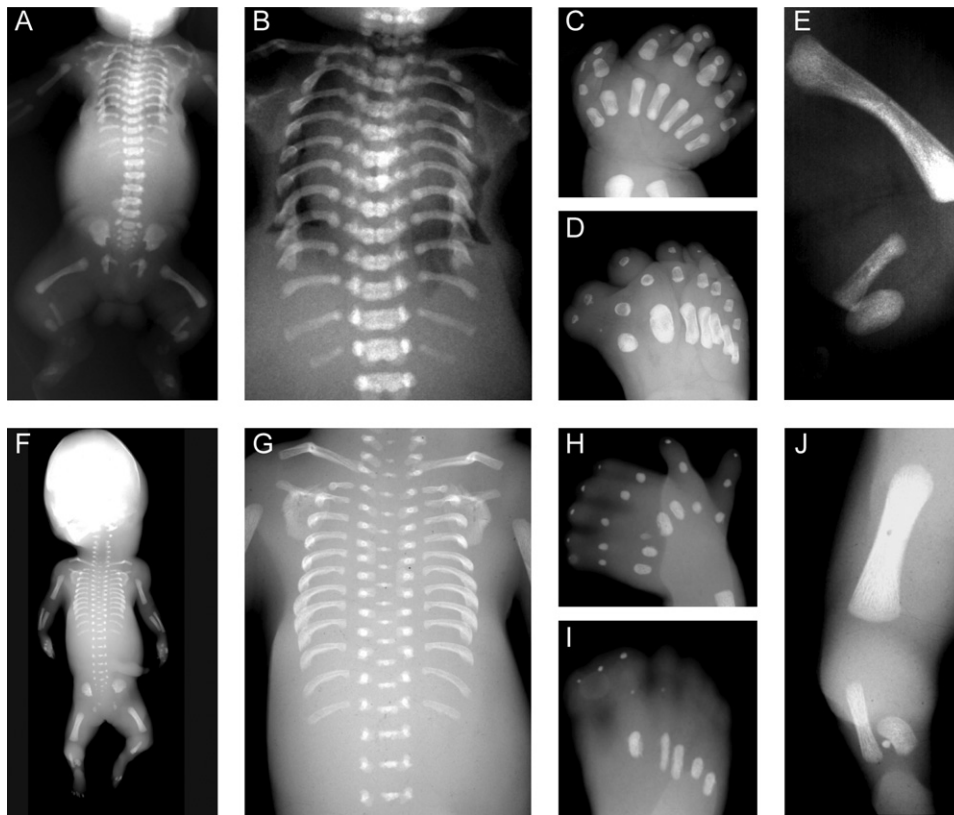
Radiographic Features of the Investigated Patients with SRPS Type Majewski
